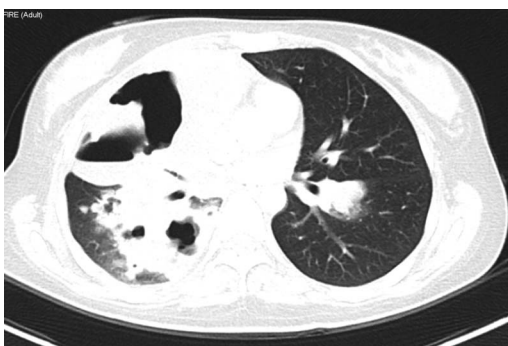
Chest CT demonstrating consolidation, cavitation and nodules.
